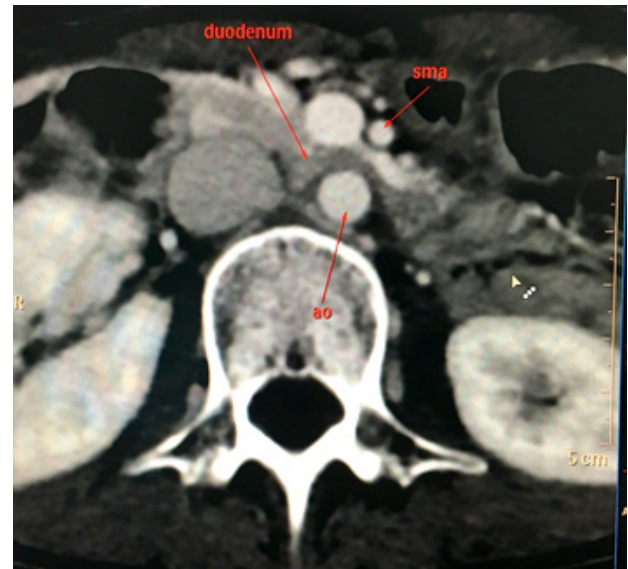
Axial computed tomography scan of the abdomen demonstrating duodenal compression by the aorta (ao) and superior mesenteric artery (sma)
